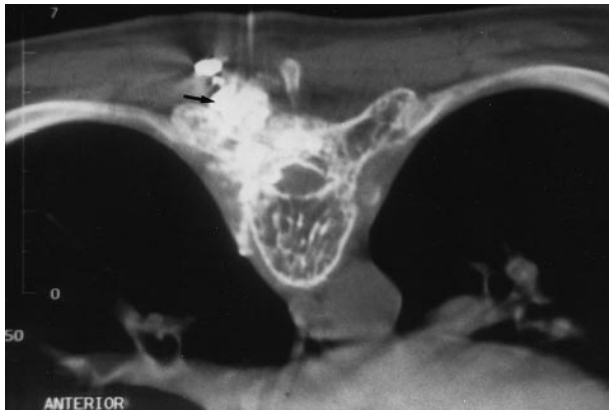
Axial CT scan obtained similarly in another patient shows extravasation of contrast into the paraspinal muscles (arrow) and pleural cavity. The procedure was abandoned at this stage.
